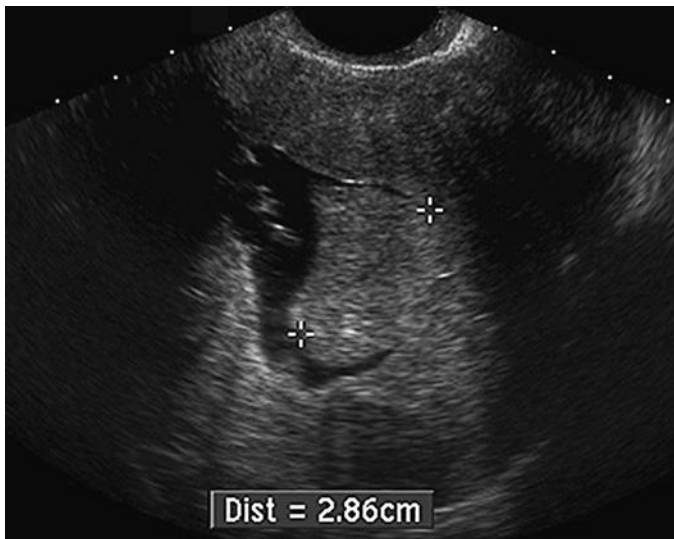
Sonohysterogram with endometrial polyp. Sagittal gray-scale transvaginal ultrasound image from a sonohysterogram. The uterus is retroflexed. Instilled anechoic intracavitary sterile saline distends the endometrial cavity and partially outlines a large (2.86 cm) echogenic polyp (*calipers*).
